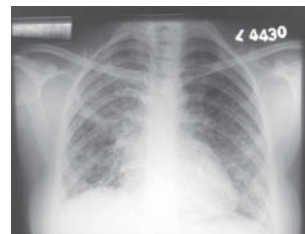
Chest Radiograph shows multiple nodules in bilateral mid and lower zones with consolidation in right upper lobe.
